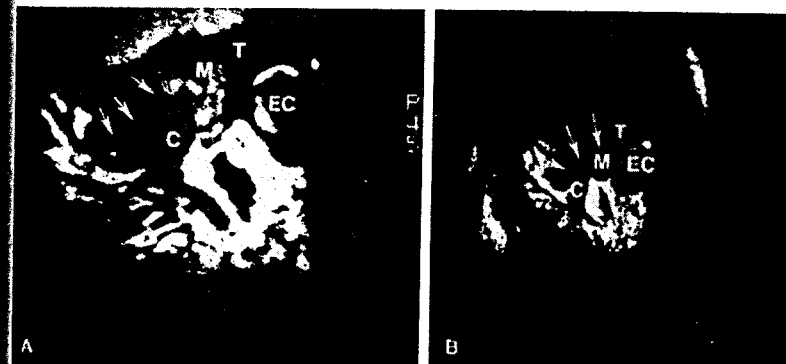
MRI images of PTIPI implants. A, Scan of left TMJ showing decreased signal of condyle (C), fragments of PTIPI (small arrows), soft-tissue mass surrounding the implant (M), and loss of temporal bone (T) with mass against the dura (large arrow). The mass does not involve the ear canal (EC). B, Scan of the TMJ with fragmentation of the PTIPI implant (arrows), severe degenerative changes and decreased signal of the condyle (C), and a large mass surrounding the implant (M). The temporal bone (T) is intact, and the mass is not affecting the ear canal (EC).
